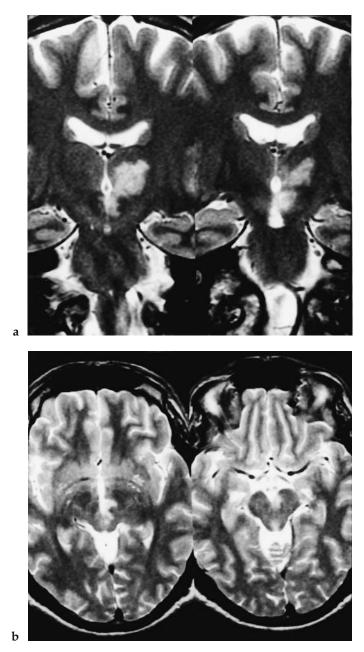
Magnetic resonance image (T2-weighted) of a patient with a mixed pattern of ocular tilt reaction to the right and a lesion of the oculomotor nucleus and fascicle on the left due to an acute paramedian thalamus midbrain infarction, which was caused by a dissection of the left vertebral artery with embolism. The left-sided lesion encompasses in the upper midbrain the region of oculomotor nuclei with the fascicle as well as the supranuclear ocular motor and vestibular centres of the interstitial nucleus of Cajal and the rostral interstitial nucleus of the medial longitudinal fascicle. The deviation of the subjective visual vertical still amounted to +4–5° for the ipsilateral left eye, and +8–10° for the contralateral right eye 1 month after the infarction; fundus photography showed an incyclorotation of the left eye of 4° and an excyclorotation of the right eye of 7°. There was additional gaze palsy for upward and downward directions.
